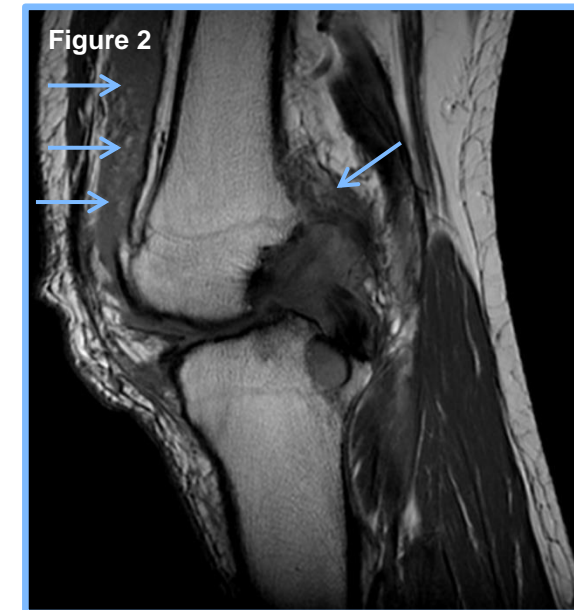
MRI proton density, sagittal oblique view of the right knee demonstrating extensive synovitis about the joint with lipoma arborescens primarily within the suprapatellar recess, and no evidence of PVNS.
